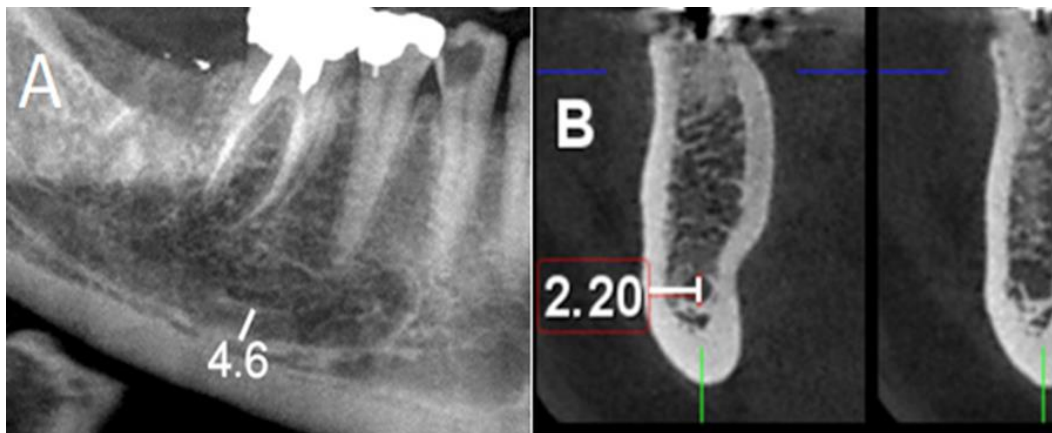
Examination of the diameter of the inferior alveolar canal. A: panoramic image, B: CBCT image.
